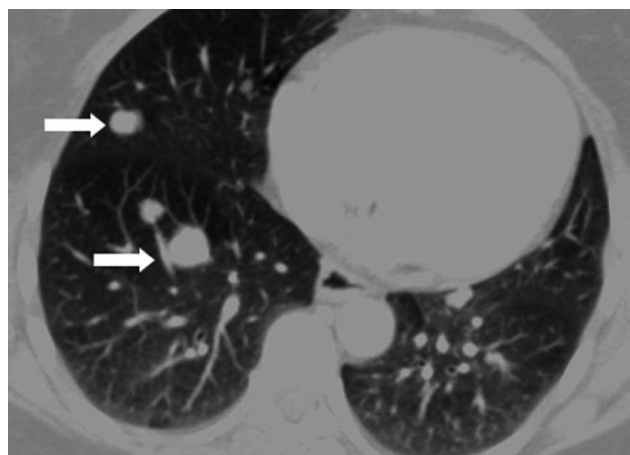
Metastatic clear cell RCC. Axial CT image of the lower thorax demonstrates multiple metastatic pulmonary metastases (arrows) from clear cell RCC.
